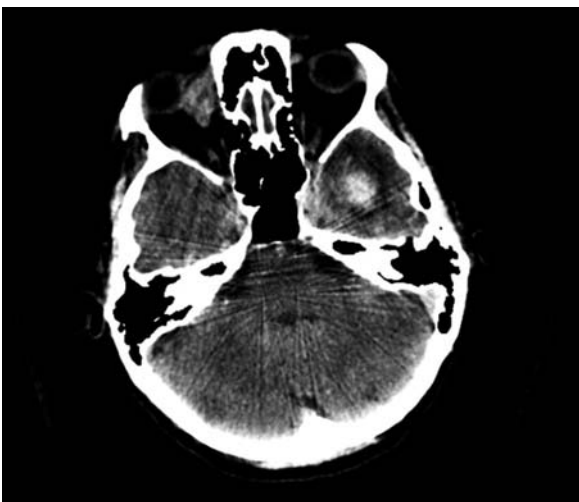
Cerebral computed tomography. Right ocular metastases
